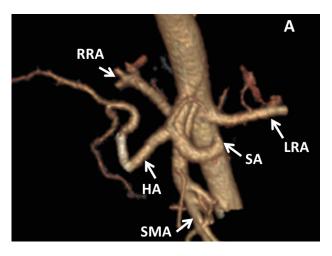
Female patient, 22 years old, 2 years after othotopic liver transplantation, and hepatic artery stenting. On control Doppler ultrasound exam suspicion of arterial stenosis, so CTA and DSA was done. A. CTA arterial phase 3D reconstruction, hepatic artery stenosis (75 %) at the proximal part of endoluminal stent, baucause of stent angulation. B. Digital subtraction angiography shows hepatic artery stenosis baloon dilatation was successfully performed. CTA – computed tomography angiography; DSA – digital subtraction angiography; RRA – right renal artery; LRA – left renal artery. HA – hepatic artery; SMA – superior mesenteric artery; SA – splenic artery;
